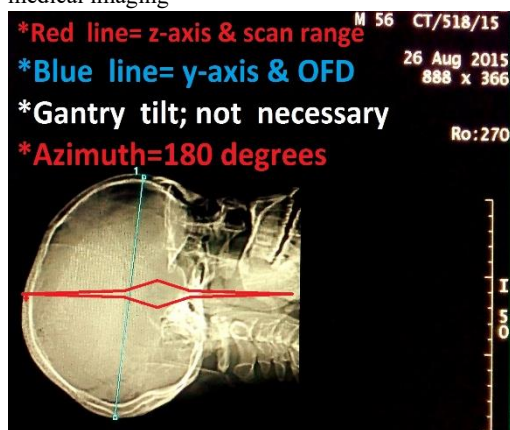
Head CT image showing positioning landmarks
